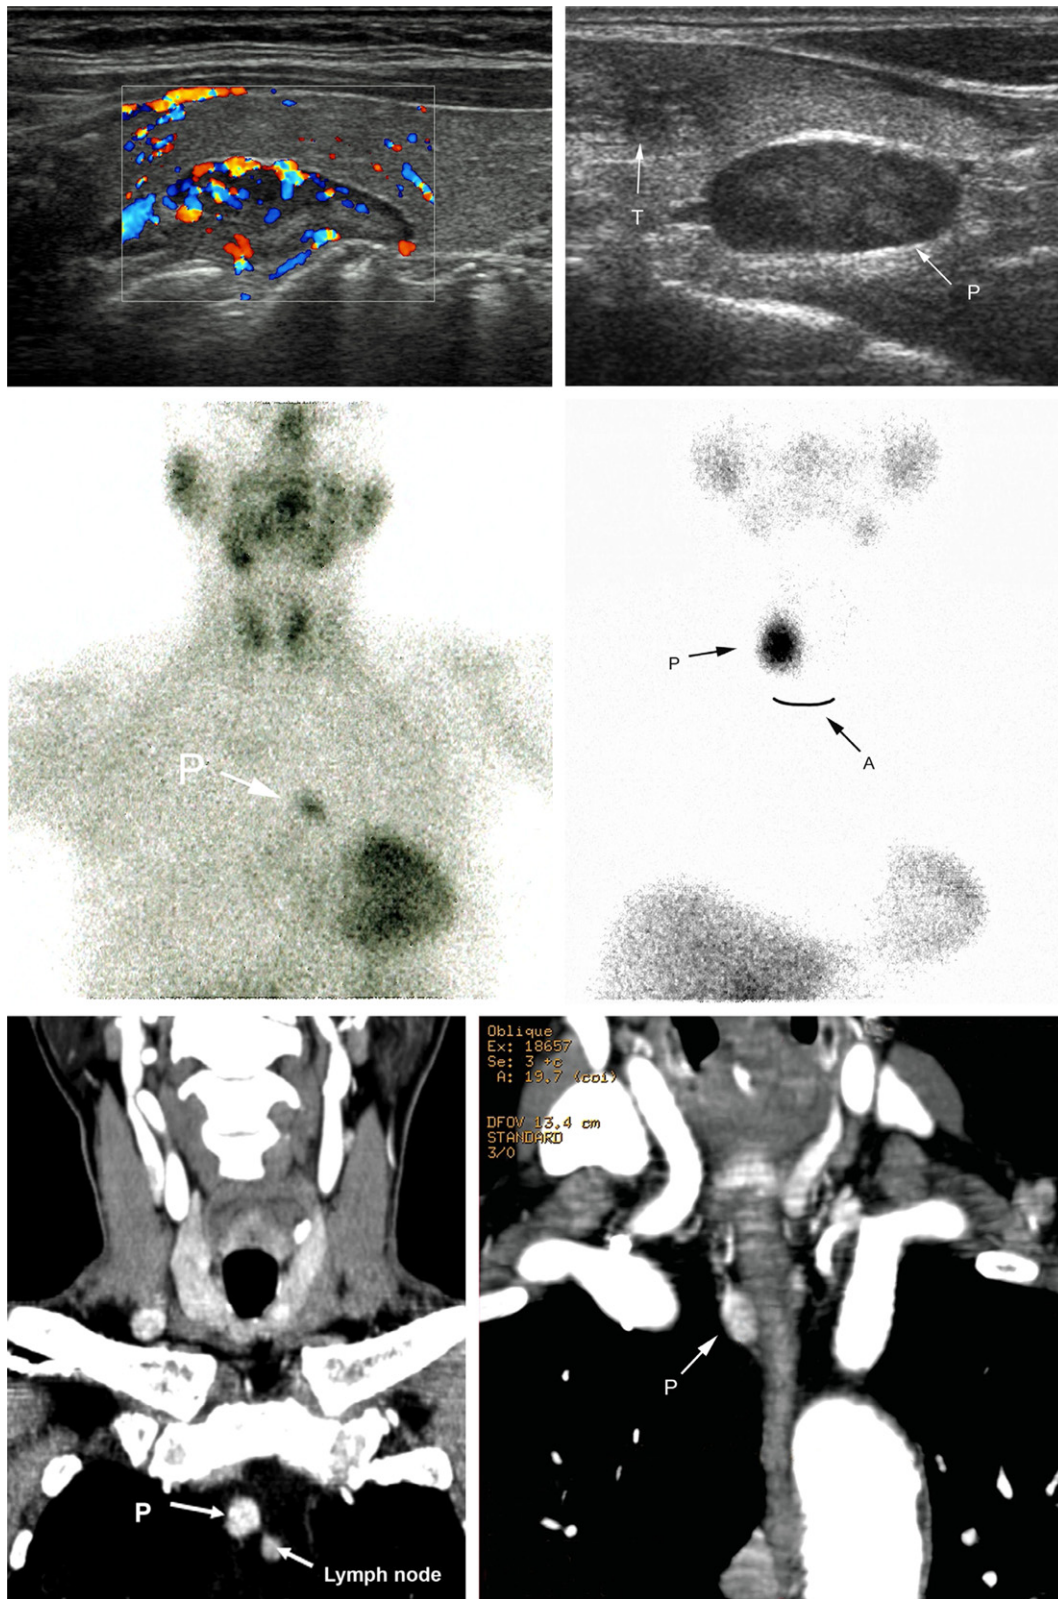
Parathyroid imaging. *Upper panels:* Ultrasound. *Left:* Typical hypoechoic pattern and shape of a lower parathyroid adenoma (P) adjacent to the thyroid lobe (T). *Right:* Color power Doppler ultrasound pattern of a parathyroid adenoma, showing a diffuse intraparenchymal color flow signals. *Central panels:* 99m -technetium-sestamibi scanning. *Left:* parathyroid adenoma (P) in the right lower neck; (A) indicates jugular dimple. *Right:* Parathyroid adenoma (P) located in the upper mediastinum (P). *Lower panels:* CT scan. *Left:* Coronal section showing a paraesophageal parathyroid adenoma (P). *Right:* Coronal section showing an ectopic parathyroid adenoma in the upper mediastinum (P) and an adjacent lymph node (L).
